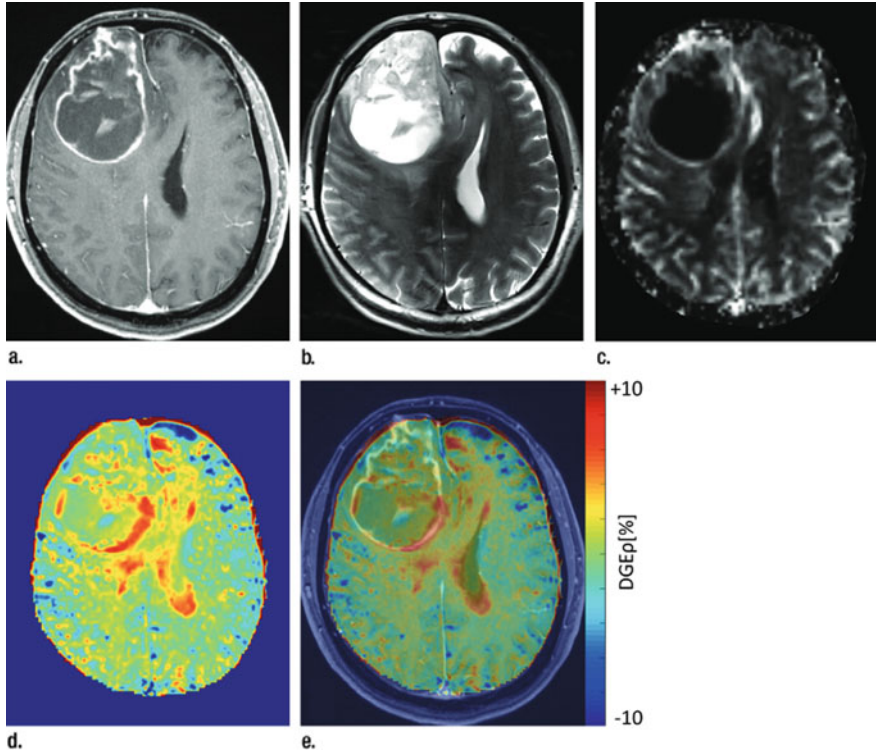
$T1\rho$ -weighted dynamic glucose-enhances ($DGE\rho$) MRI at 7T in a patient with newly diagnosed glioblastoma, compared with GdCE T1-w, T2-w and perfusion imaging. a GdCE T1-w images, b T2-w images and c rCBV maps displayed. T2-w and d $DGE\rho$ images obtained at 7T. e Fusion images of GdCE T1-w and $DGE\rho$ images. The $DGE\rho$ contrast displays regions of increased signal intensity, particularly in the dorsomedial tumor region (overlapping with the ring-enhancement on GdCE-T1), and beyond the borders of BBB disruption (e). Some regions of increased glucose uptake cannot be delineated on the GdCE T1-w, T2-w, and perfusion images. Partial overlap can be observed between $DGE\rho$ and rCBV images. Original figure from Paech et al. [173] with reprint permission from RSNA
